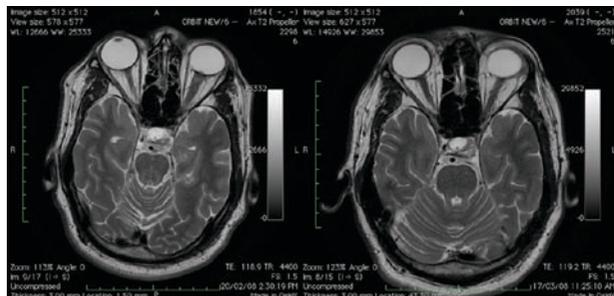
MRI of the brain and orbit: Axial T2-weighted images comparing the hypointense optic nerve thickening at presentation (left) and partial resolution at 4 weeks from presentation (right).
